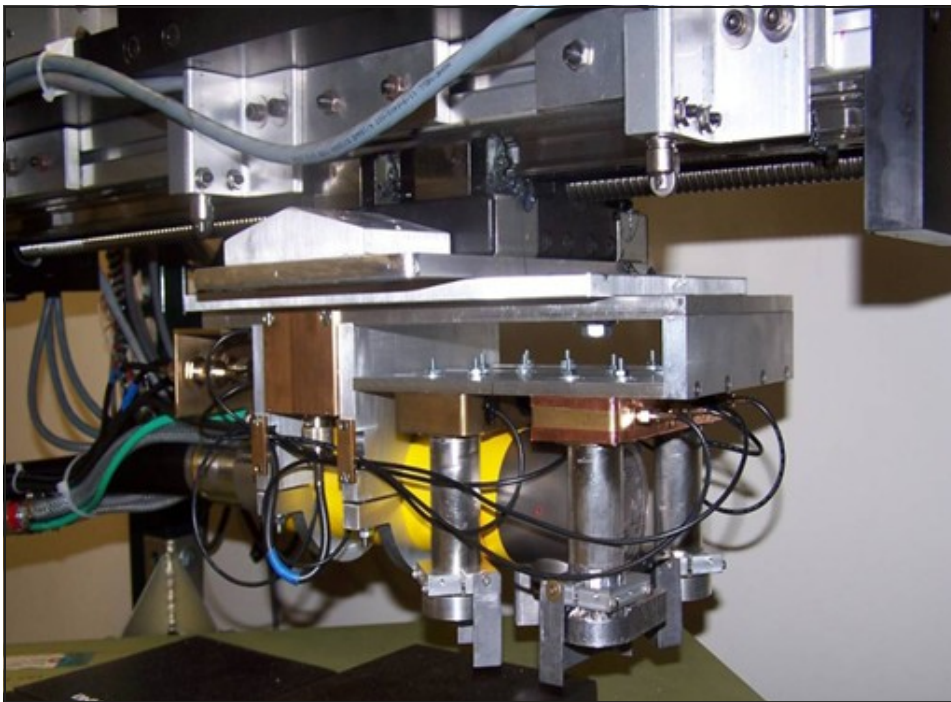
CIBR scanning system setup for proof of principle. This system consists of a compact x-ray generator and four scintillation detectors that move linearly over a rotating target table.
